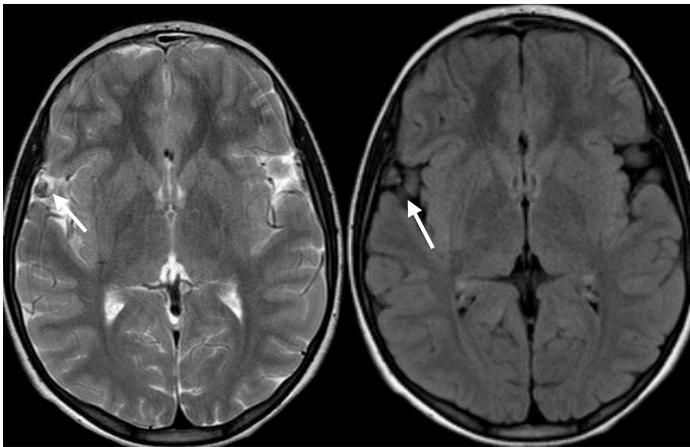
MRI in 2023 showing significant regression of the venous aneurysm 7mm x 7mm
